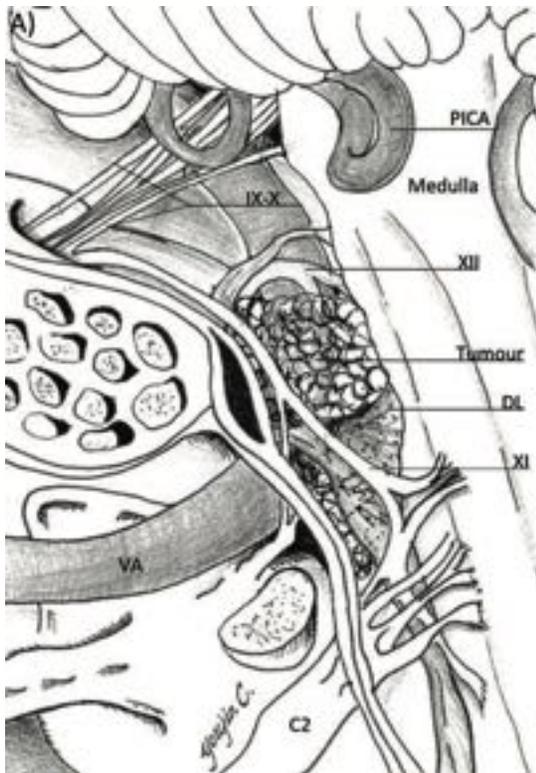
(A) Artist's depiction of the surgeon's intraoperative view of the anterolateral foramen magnum meningioma. Note that most of the tumor is anterior to the dentate ligament and by definition is classified as anterolateral. The spinal component of nerve XI is on the surgeon's side of the tumor, and care should be taken not to injure it or mistake it for a leaf of the dentate ligament. (B) Intraoperative photograph demonstrating pathological displacement of anatomical structures of an anterolateral foramen magnum meningioma. A standard suboccipital craniectomy was performed without resection of the condyle. Tumor (*) is noted through intact arachnoid to the left of the rostral spinal cord and is draped with various nerve rootlets (arrows) and blood vessels. CH, cerebellar hemisphere; CT, cerebellar tonsil; FM, rim of foramen magnum; C2, C2 segmental nerve root; DT, dentate ligament; PICA, post inferior cerebellar artery; VA, vertebral artery. Used with permission from Boulton MR, Cusimano MD. Foramen magnum meningiomas: concepts, classifications, and nuances. *Neurosurg Focus* 2003;14(6):e10.
